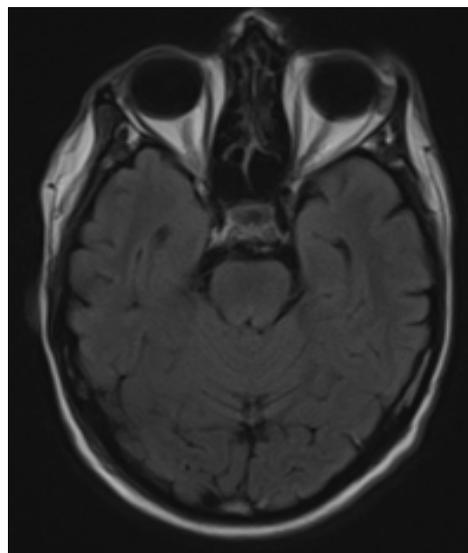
MRI brain showing near complete resolution of previously seen signal abnormality in bilateral hippocampi.
